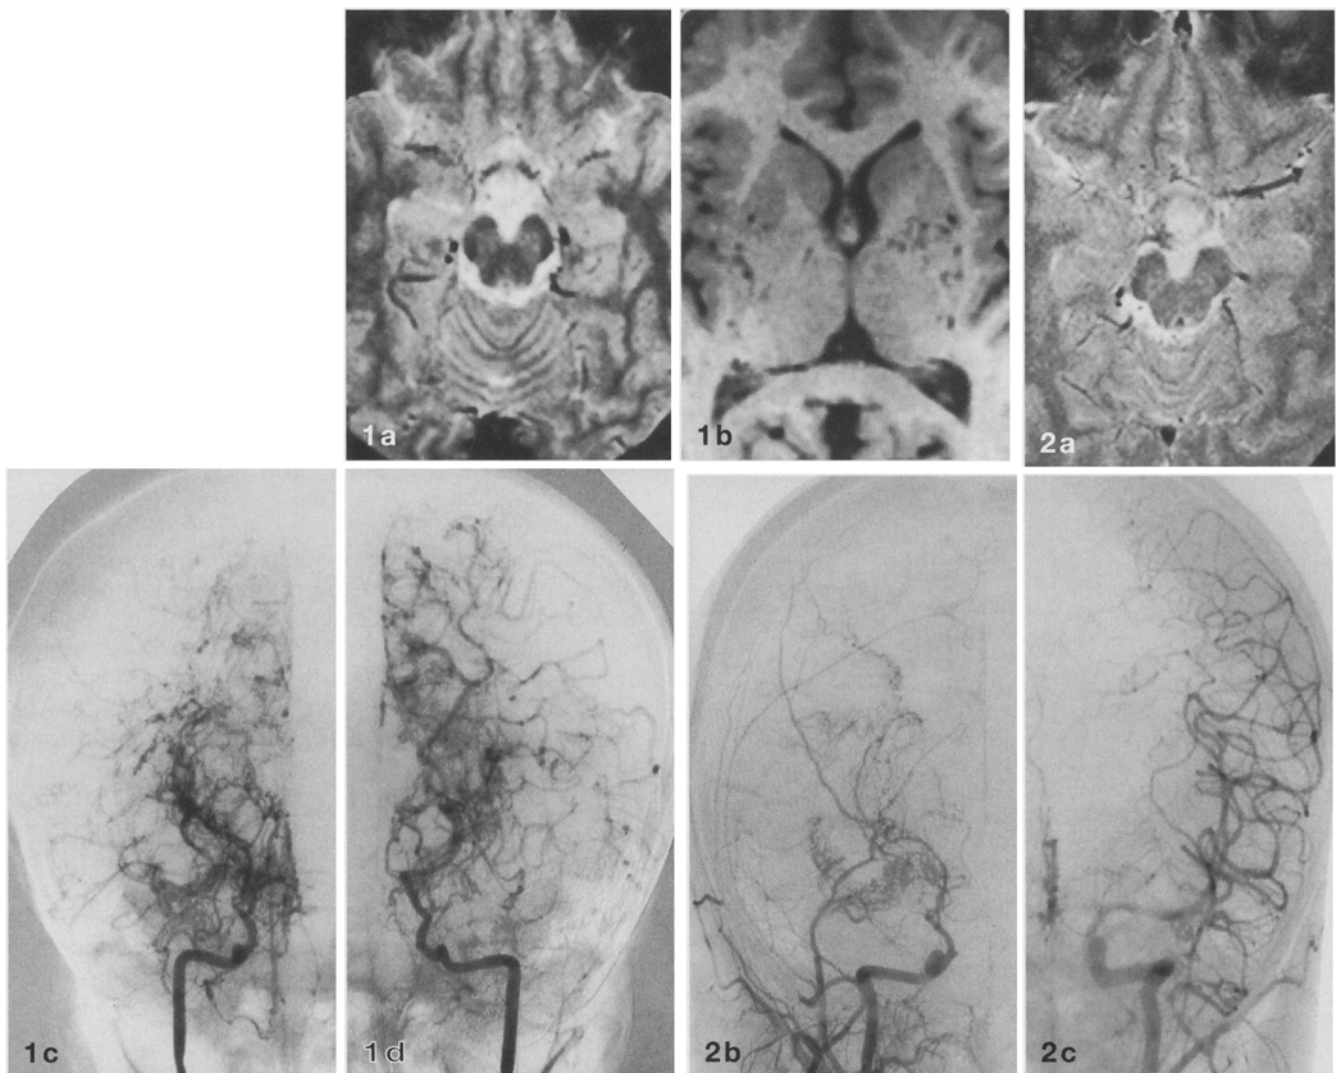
A 7-year-old boy. a Axial T2-weighted image shows that the supraclinoid ICA and proximal ACA and MCA are occluded bilaterally. b Axial T1-weighted image shows marked bilateral moyamoya vessels (MMV). c, d Right and left internal carotid arteriography, frontal projection, show that both ICA are occluded in the distal supraclinoid portion and the ACA and MCA in their proximal portions. Marked MMV are seen
